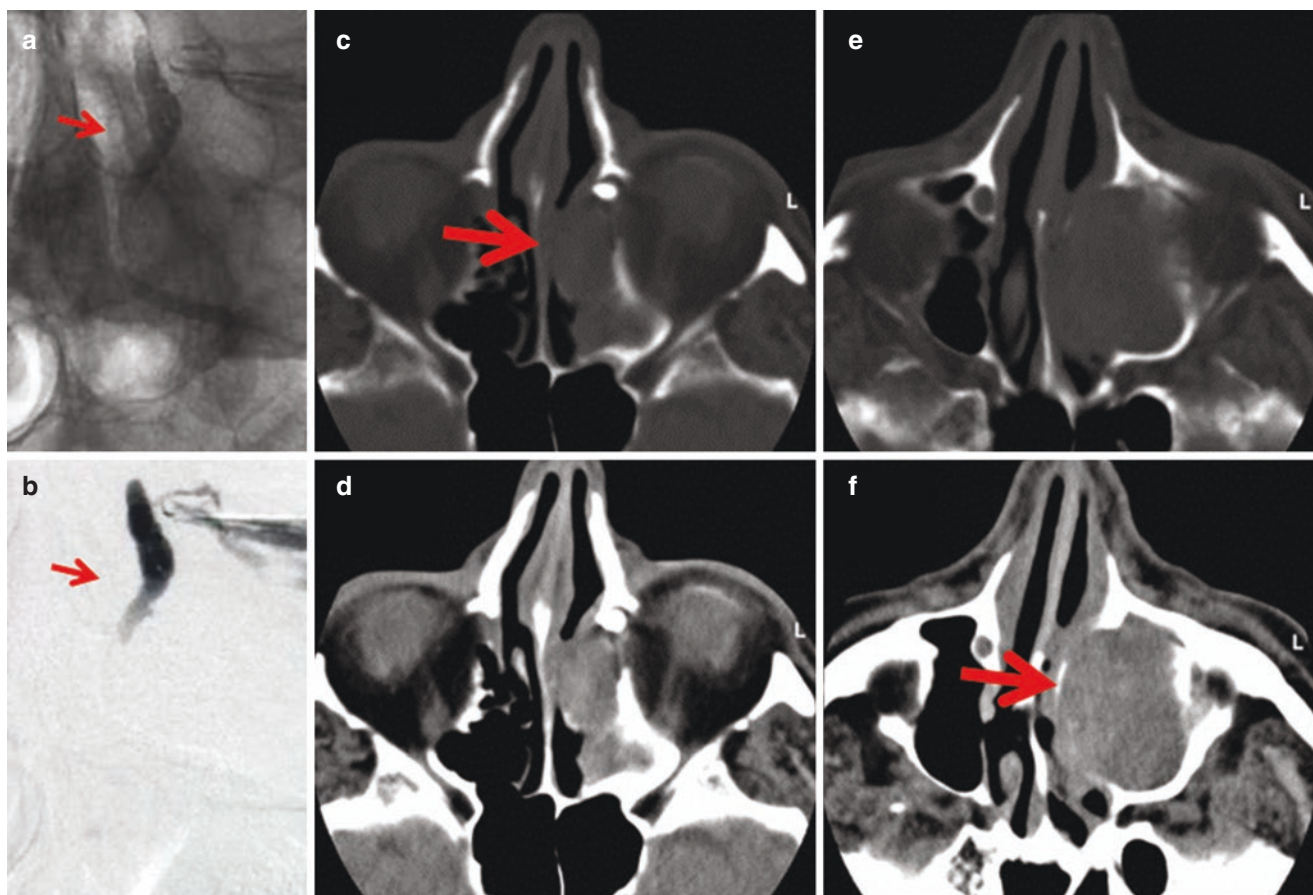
Inverted papilloma: (a) dacryocystography (DCG), (b) digital subtraction dacryocystography (DSD), and (c–f) computed tomography (CT) showing the nasolacrimal duct is deviated by a mass
